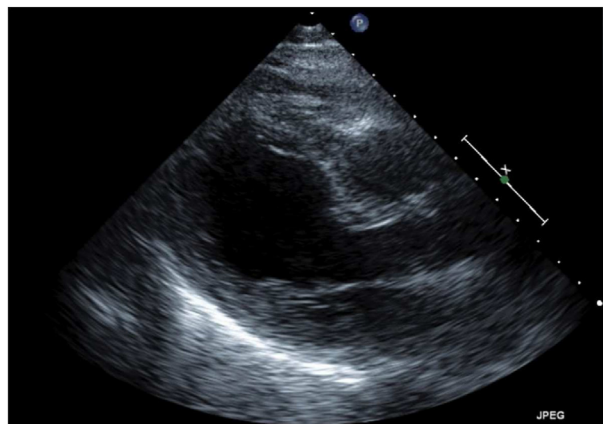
Echocardiogram para-sternal long axis view showing dilated and ballooned LV.
